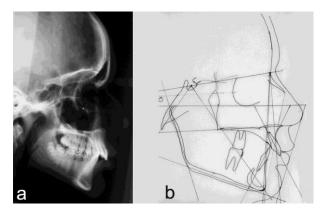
a) Lateral head radiograph before therapy; b) Cephalometric tracing before therapy.
